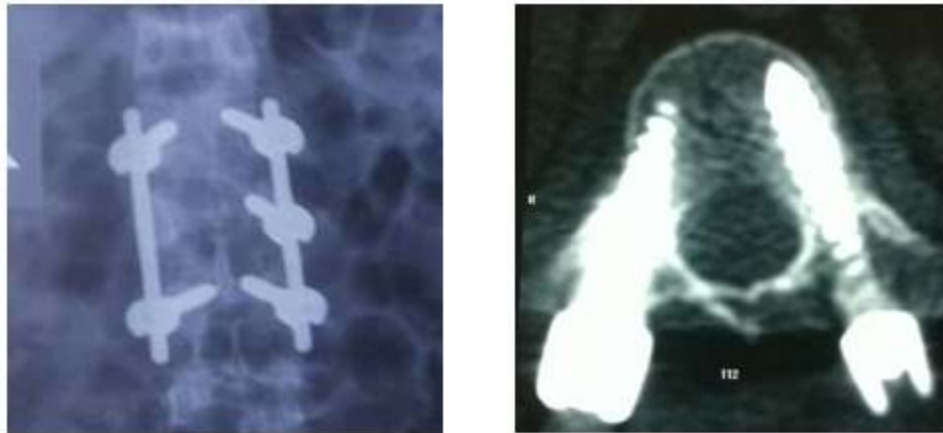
A) X ray of operated L4 burst fracture in which the left pedicle screw in L5 appears to be breaching on lateral side, B) But the CT of same patient shows no breach for that screw.
